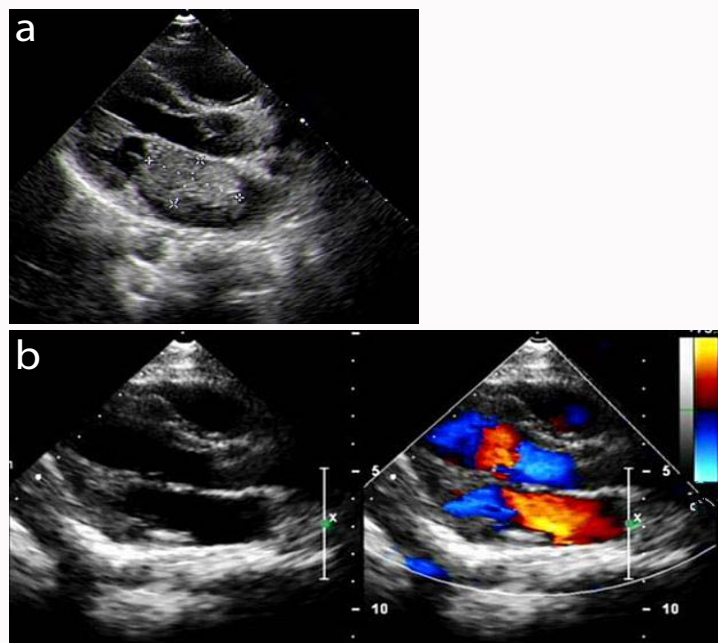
Preoperative (1a) and postoperative (1b) ultrasound examination of atrial myxoma.
